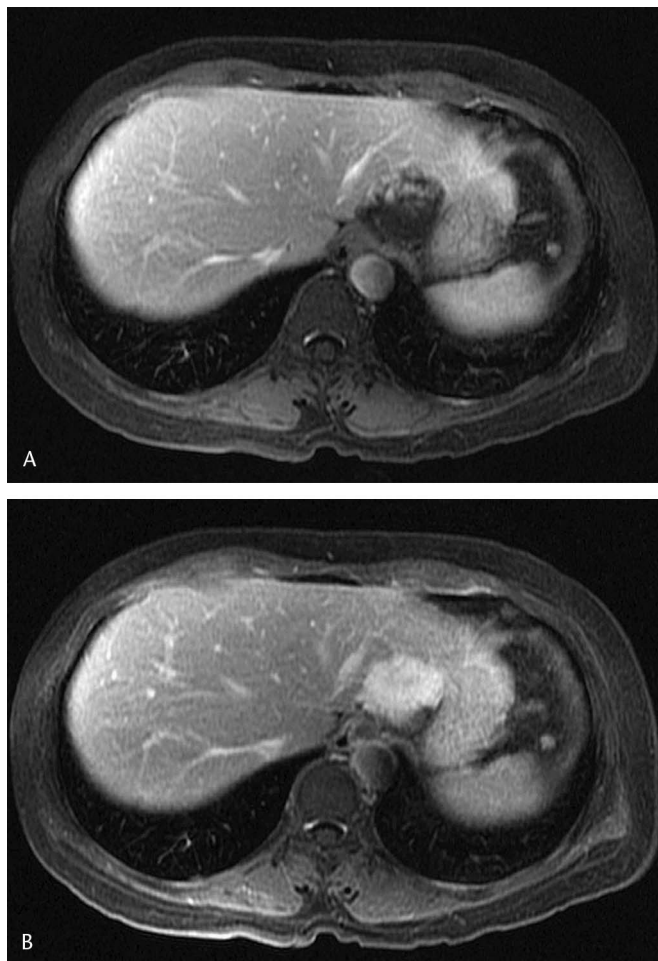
Hemangioma. A, Early enhanced T1-weighted image reveals peripheral nodular enhancement of the tumor. B, Delayed enhanced T1-weighted image shows homogeneous enhancement of the tumor.
